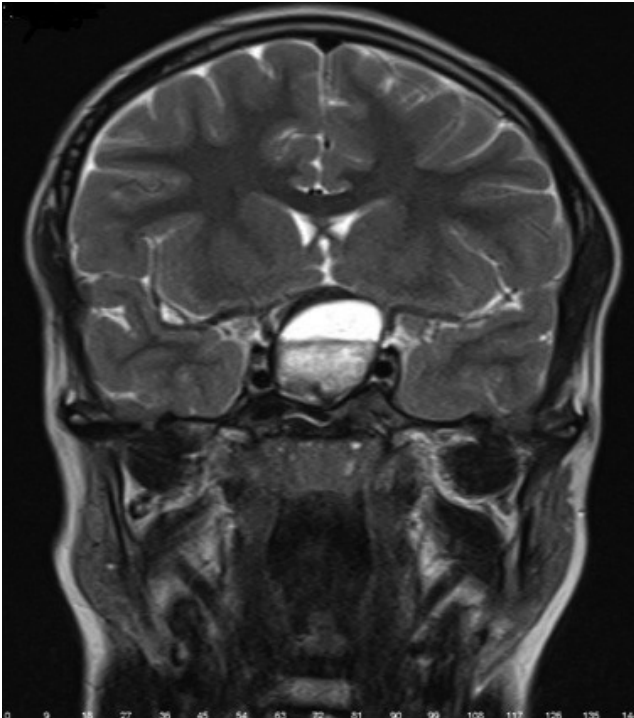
In the cranial magnetic resonance imaging coronal slice, a sellar/suprasellar intracranial mass was observed
